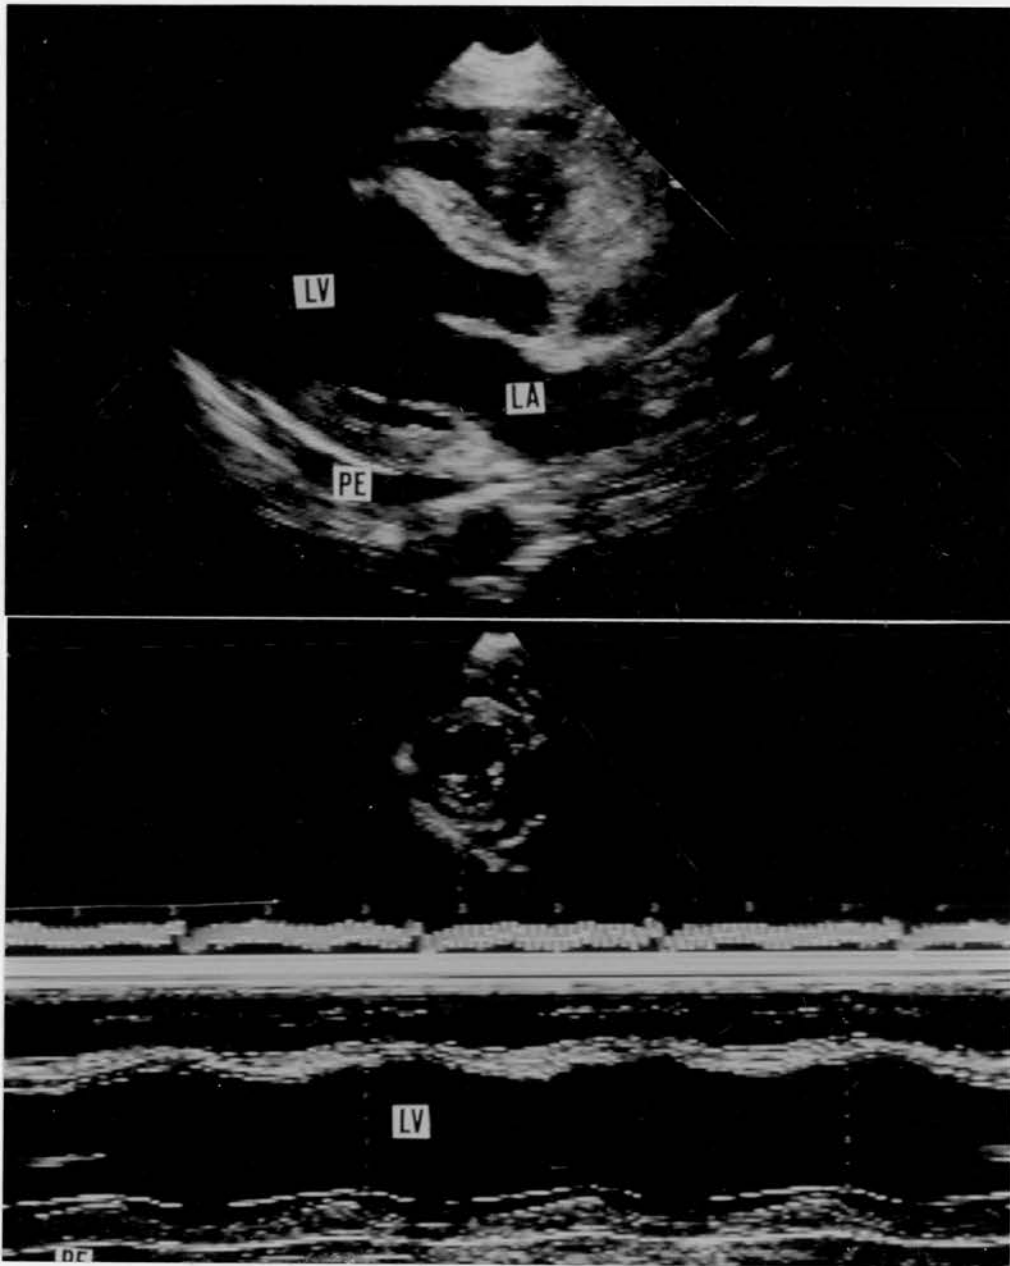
Pericardial effusion in parasternal long axis and M-mode echocardiograms (short axis view).
